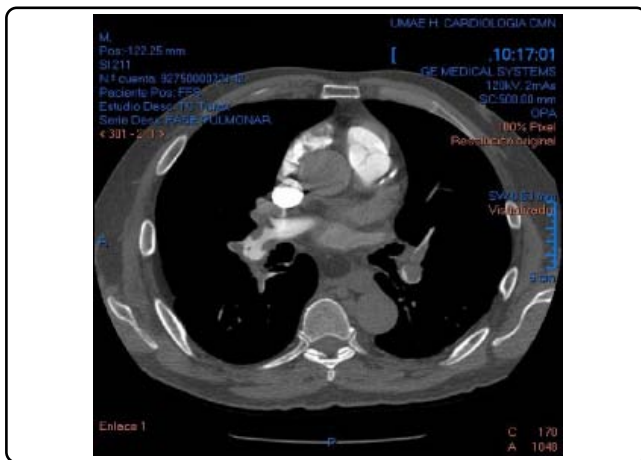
CT axial scan shows the right and left main pulmonary arteries, there is an almost 90% of obstruction on the left side and 80% on the right.
